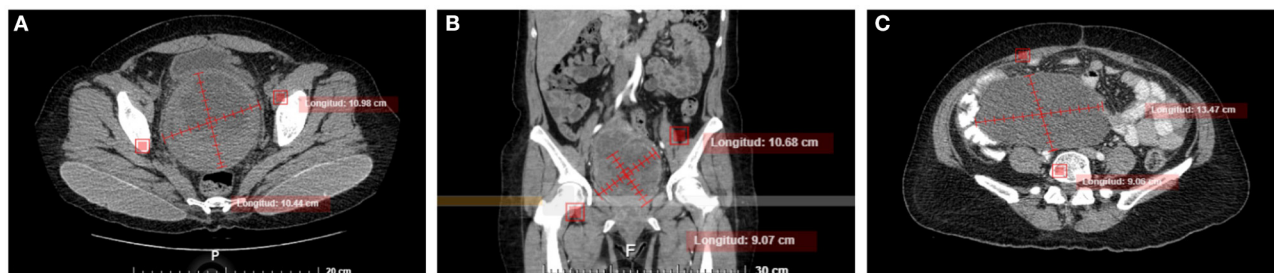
Abdominal axial (A) and coronal (B) non-enhanced CT images show a large well-defined rounded tumor, with a heterogeneous appearance in the cervix and demonstrating mass effect in adjacent structures and preserving interface with the bladder wall and rectum. (C) Axial non-enhanced CT, three months after surgery shows a heterogeneous abdominal tumor that compresses and displaces adjacent structures.
